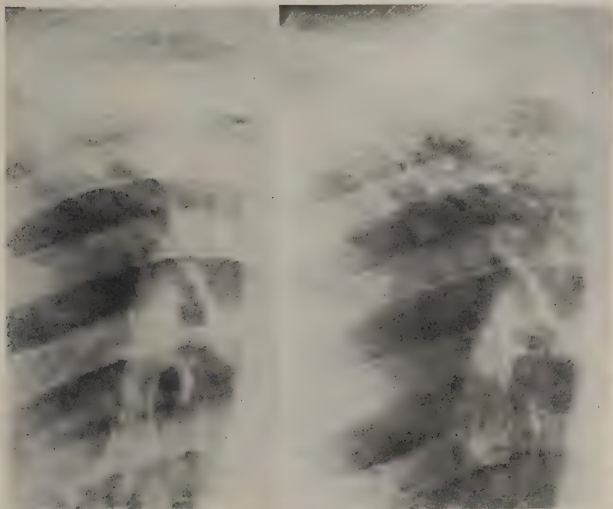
(Case 4). A (Left). Roentgenogram, taken on September 16, 1943, showing a lesion in the right apex down to the second rib in front.
